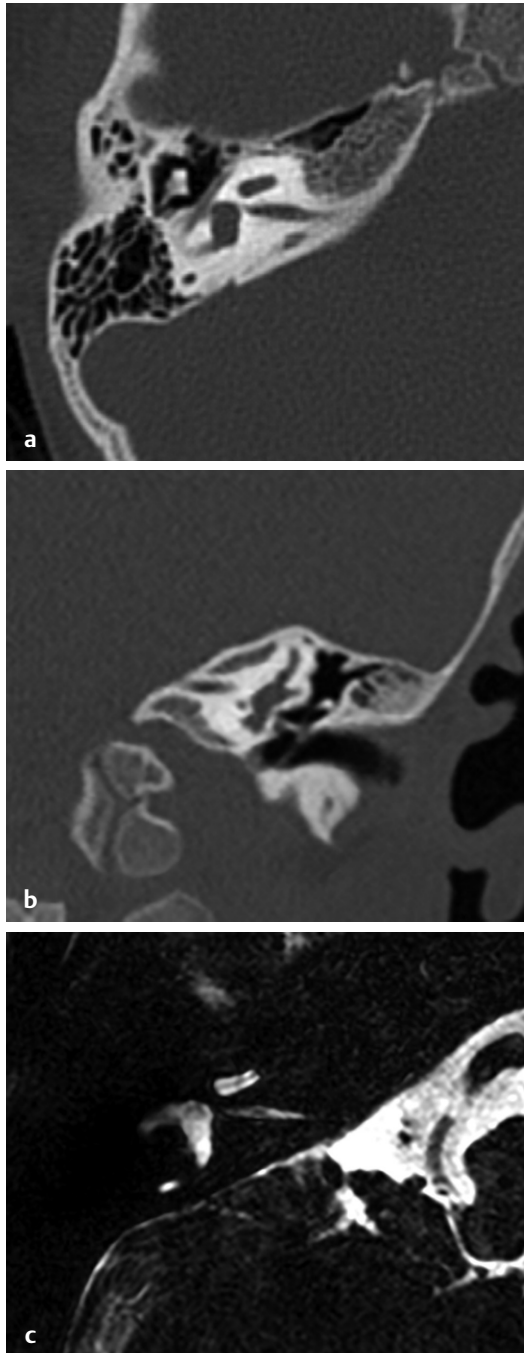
HRCT temporal bone, bone window, (a) axial section, (b) coronal section, and (c) MRI CISS sequence axial section shows narrow internal acoustic canal in normal inner ear.
